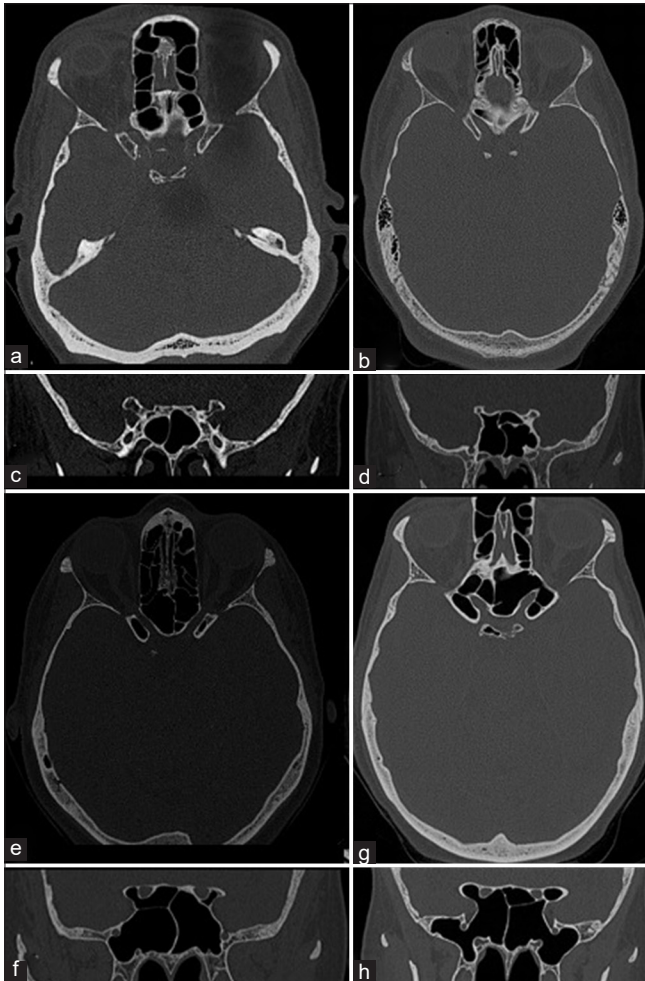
This is a panel of skull-based computed tomography containing all the examples of each type of anterior clinoid. (a and b) The axial and coronal views of a Type 0, absence of pneumatization. (c and d) The axial and coronal views of a Type 1, pneumatization of the optic strut without anterior clinoid pneumatization. (e and f) The axial and coronal views of Type 2A (left side) and 2B (right side), this subtype presents a pneumatized anterior clinoid and optic strut, the difference is the volume of pneumatization in the anterior clinoid, the Type 2A has less than 50% and the Type 2b has more than 50% of aeration. (g and h) The axial and coronal views of Type 3, pneumatization of the anterior clinoid, optic strut, and planum sphenoidale.
